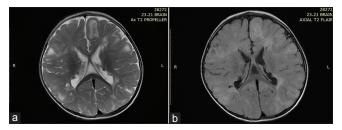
(a and b) Subependymal nodules along the walls of lateral ventricles appearing hypointense on T2/FLAIR image
